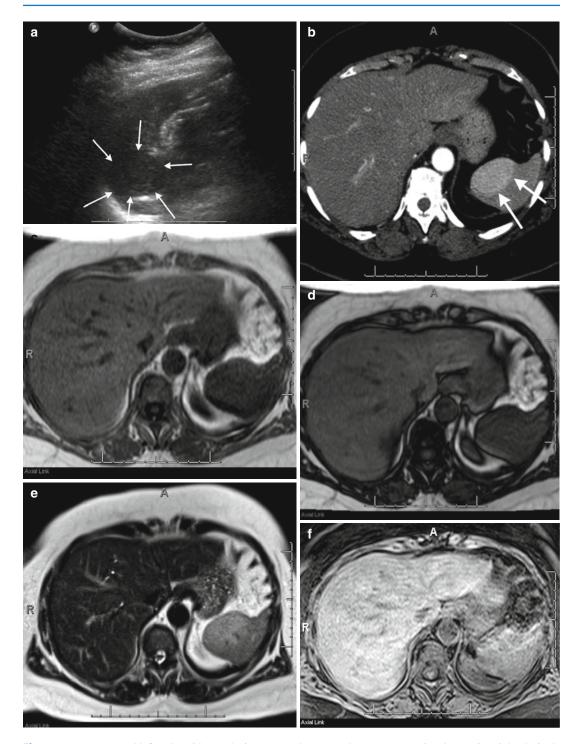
A 71-year-old female with a splenic mass. Sagittal ultrasound of the spleen (a) demonstrates a solid mass arising from the upper pole of the spleen (*arrows*) with corresponding early arterial phase enhancement (*arrows*) on an axial-enhanced CT image (b). This mass shows isointense signal with splenic parenchyma on T1-weighted in-phase (c) and out-of-phase (d) imaging
